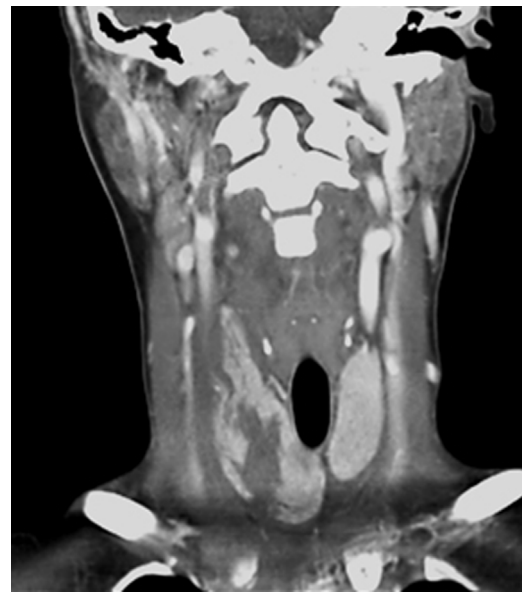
CT scan demonstrating parenchymal rupture and hematoma of the right lobe.
